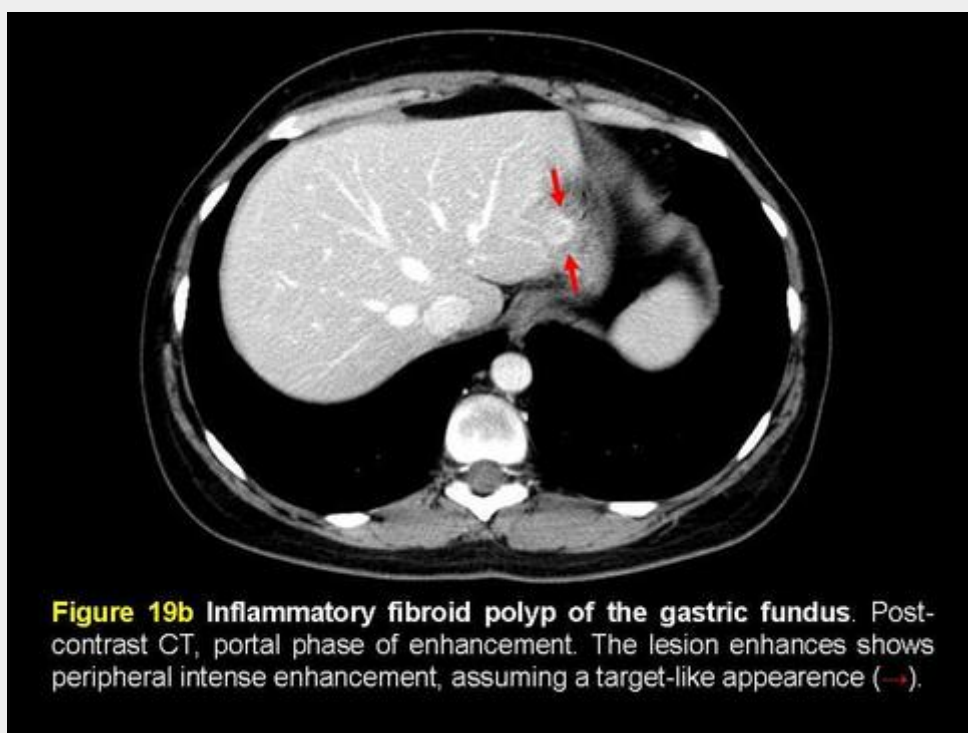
Inflammatory fibroid polyp of the gastric fundus. Post-contrast CT, portal phase of enhancement. The lesion enhances showing peripheral intense enhancement, assuming a target-like appearance (→).
